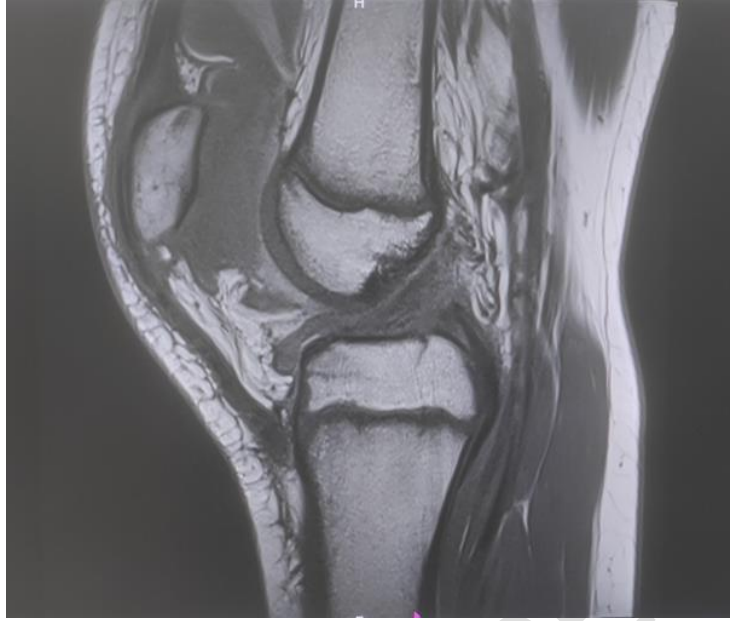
MRI of right knee showing patella sleeve avulsion
